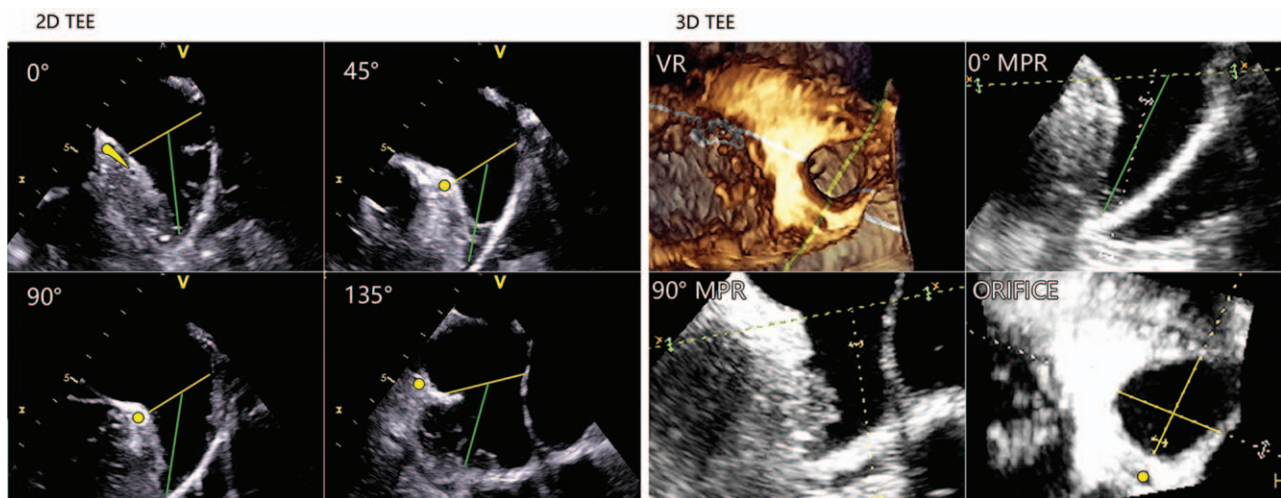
Measurement of LAA ostial dimensions using 2D (left panel) and 3D flexi slice (right panel). The LAA orifice was completely displayed as a circle instead of a single-plane measurement via 2D TEE. Yellow line: ostial dimension; green line: LAA depth. The yellow dots or raindrops in the left panel represented the left circumflex coronary artery. LAA = left atrial appendage, 2D TEE = two-dimensional transesophageal echocardiography.
